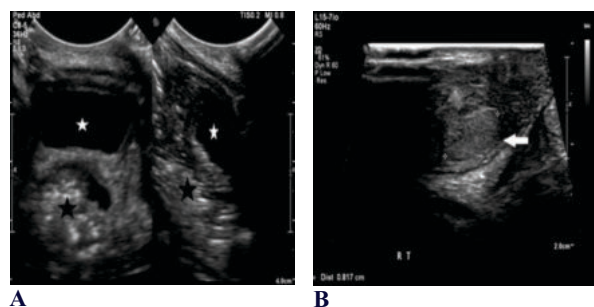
Ultrasound pelvis demonstrates presence of the uterus. No ovaries were visualized.
